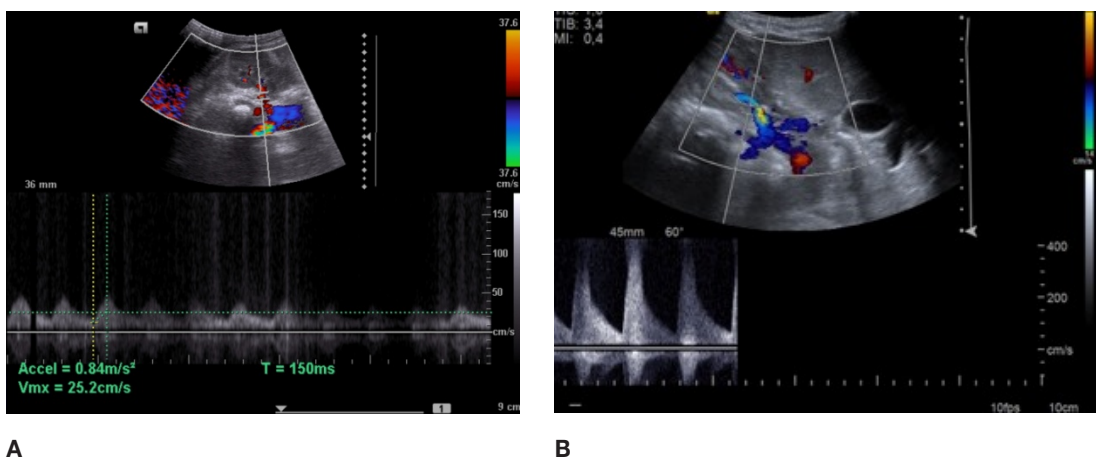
A- Doppler US: reduced intrarenal RI on the right kidney (0,56) with increased systolic ascension time (“parvus tardus” morphology). B- Doppler US: There was increased peak systolic velocity (note the aliasing effect on the image despite the scale being adjusted for 200 cm/s) and increased turbulence at the renal artery.
